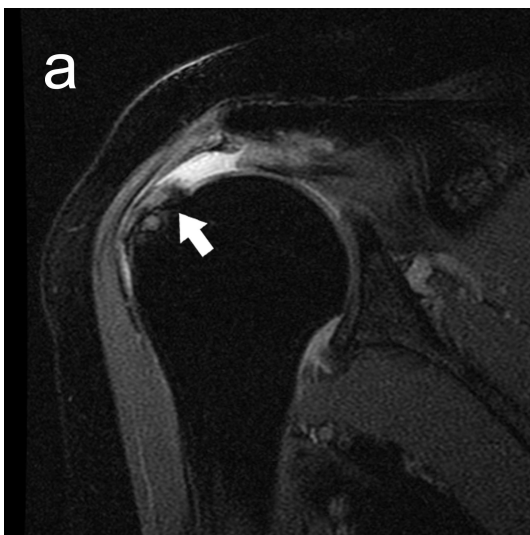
51-year-old man with traumatic rotator cuff tear. Tendon stump left on the greater tuberosity (white arrow) on the fat-saturated T1-weighted oblique coronal image.
